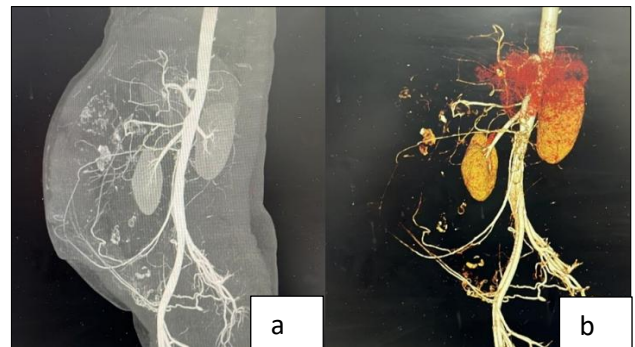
(a and b): CT angiography of the abdominal aorta.
